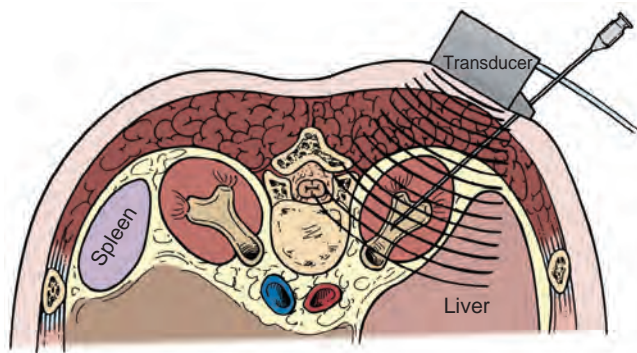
Ultrasonographic guidance of puncture needle.
